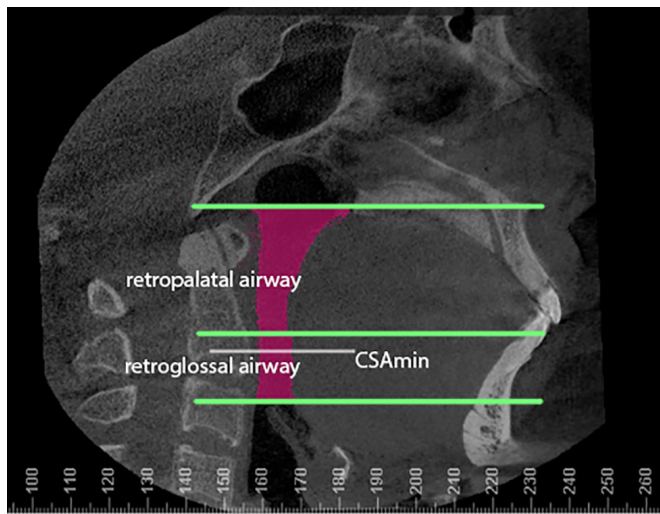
Segments of the upper airway on midsagittal CBCT image using Dolphin software (Dolphin Imaging & Management Solutions, Chatsworth, Calif). Retropalatal airway: from the plane of ANS-PNS to the plane crossing the most posteroinferior point of the soft palate; retroglossal airway: from the plane crossing the most posteroinferior point of the soft palate to the plane crossing the most superior point of the epiglottis. Minimum cross-sectional area of upper airway (CSA_{\min}) was automatically identified and calculated by the Dolphin software
